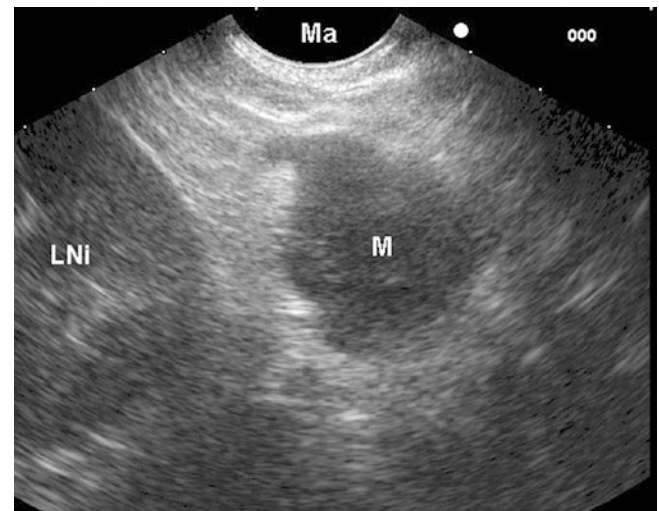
Endosonography. Enlarged left adrenal gland with metastatic involvement (M) as assessed by transesophageal sonography
